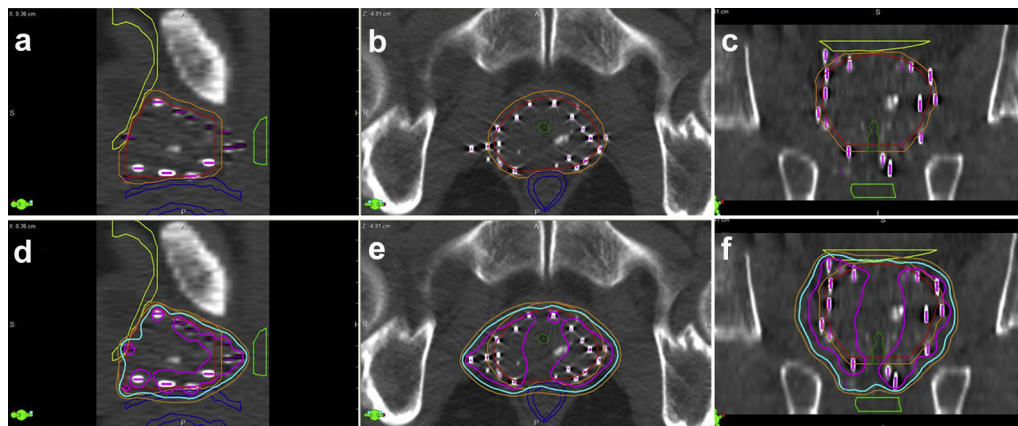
Prostate dosimetry postimplant scans. Structures were contoured on MR and fused with CT scan to identify the brachytherapy seeds. First row shows (a) sagittal, (b) axial, and (c) coronal views of pelvis. Prostate (red), bladder (yellow), rectum (blue), prostate clinical target volume (bronze). Second row shows the same (d) sagittal, (e) axial, and (f) coronal views of pelvis with isodoses overlaid (yellow 80%, blue 100%, and pink 150%). (For interpretation of references to color in this figure legend, the reader is referred to the web version of this article.)
